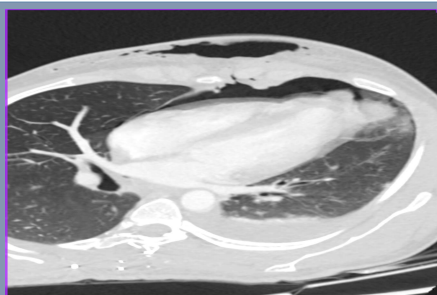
Reconstructed lung window CT image at 4 chamber cardiac plane shows communicating pneumothorax, pneumopericardium, pneumomediastinum and subcutaneous emphysema at the anterior chest wall. Inferior lingula and left posterior basal contusion with hemothorax.
